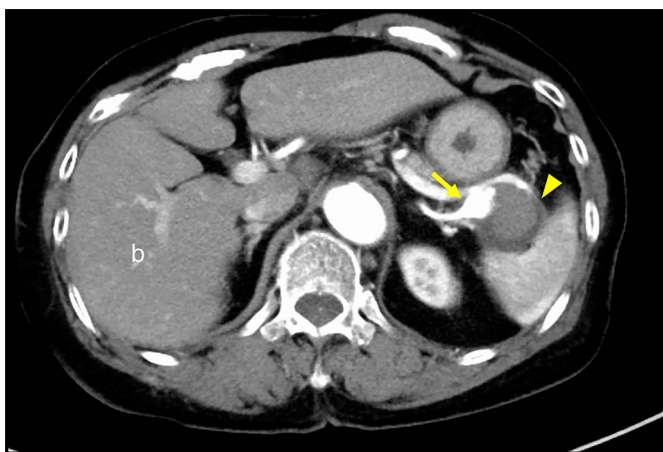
Enhanced computed tomography showed splenic arterial aneurysm ruptured for pancreatic cyst. Splenic arterial aneurysm (arrow) and pancreatic cyst with hemorrhage (arrowhead).
